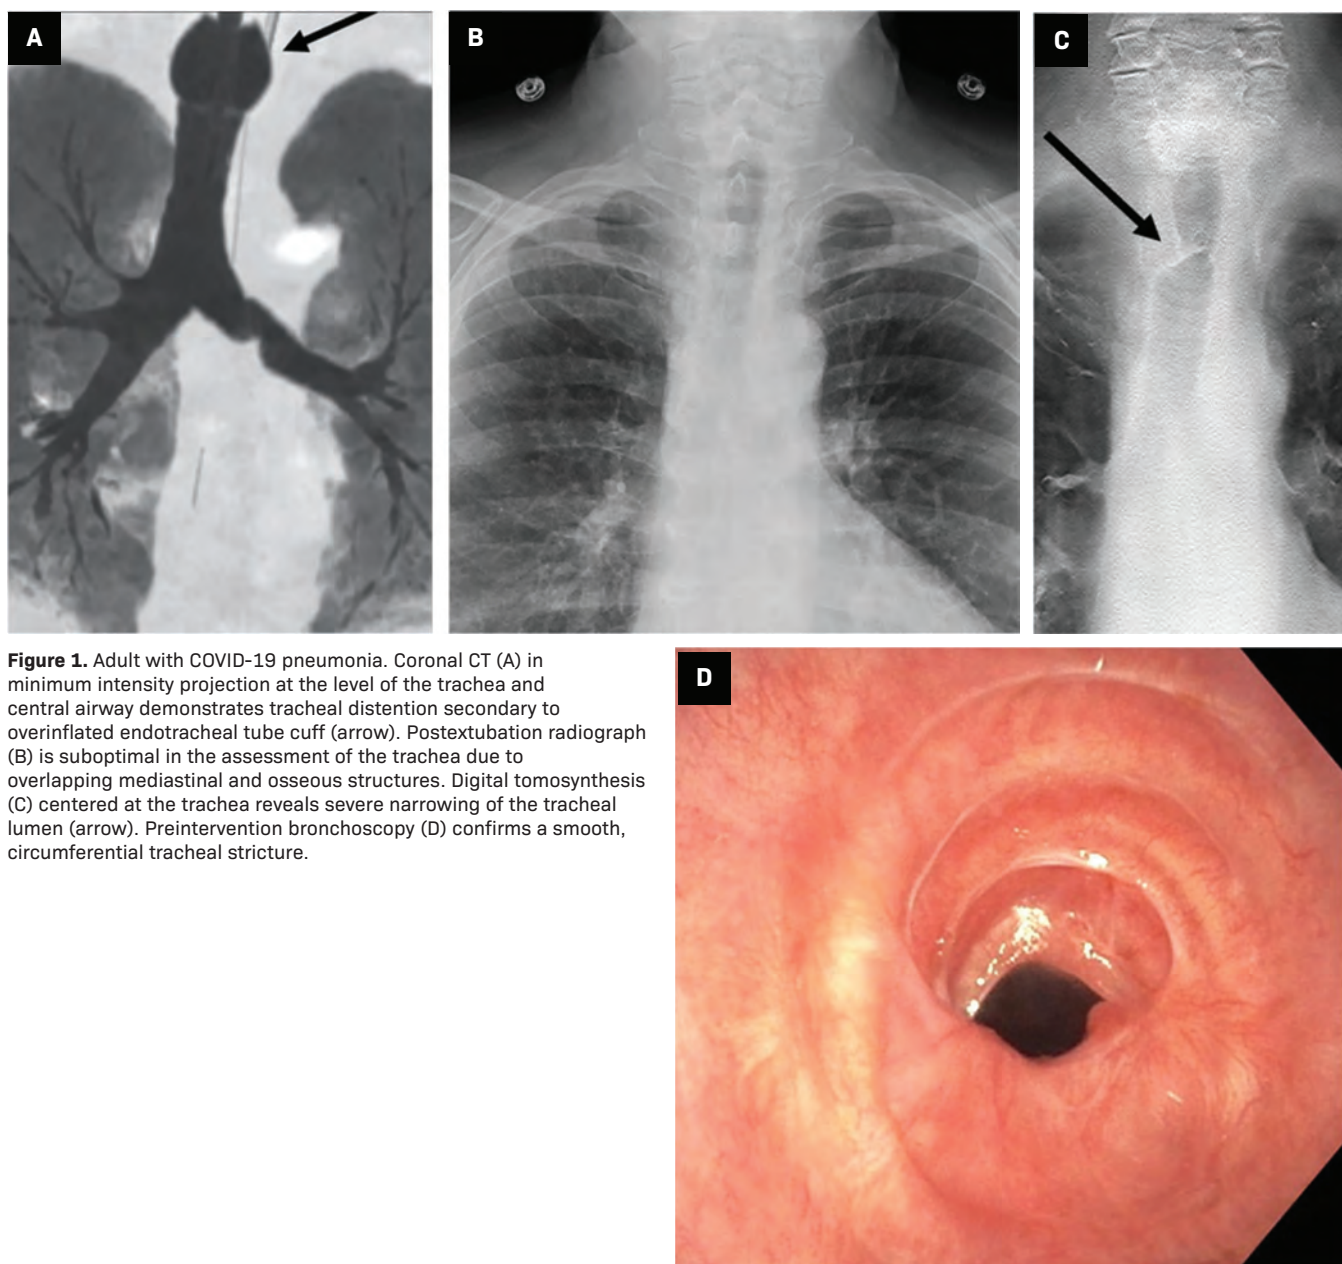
Adult with COVID-19 pneumonia. Coronal CT (A) in minimum intensity projection at the level of the trachea and central airway demonstrates tracheal distention secondary to overinflated endotracheal tube cuff (arrow). Postextubation radiograph (B) is suboptimal in the assessment of the trachea due to overlapping mediastinal and osseous structures. Digital tomosynthesis (C) centered at the trachea reveals severe narrowing of the tracheal lumen (arrow). Preintervention bronchoscopy (D) confirms a smooth, circumferential tracheal stricture.
